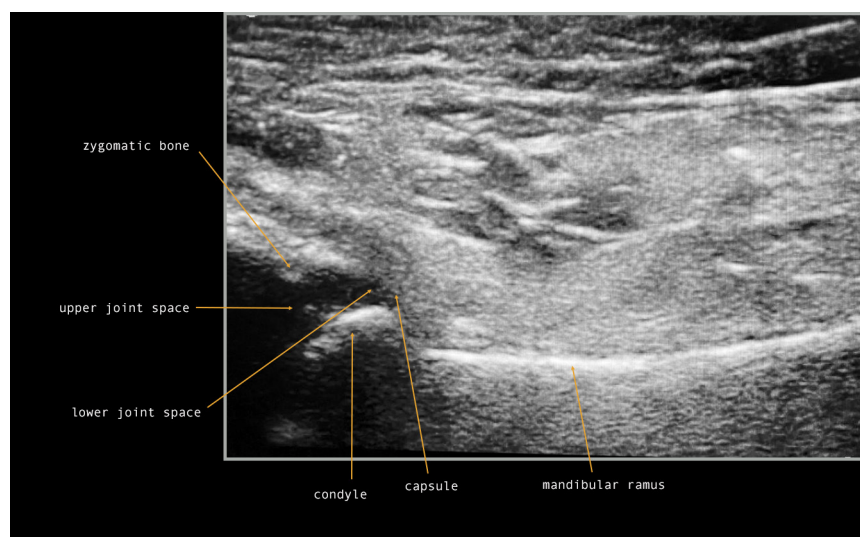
Ultrasound (US) anatomy of the temporomandibular joint (TMJ) in the coronal plane
